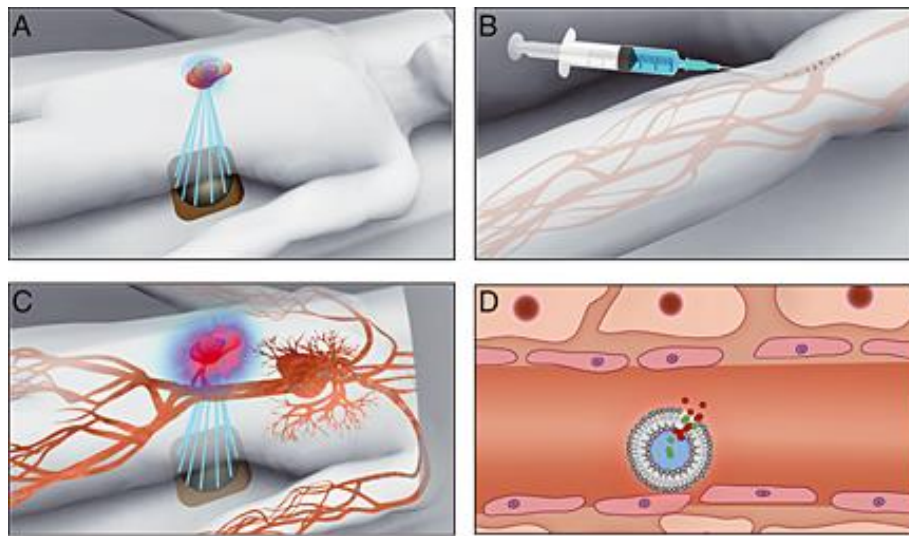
Representation of temperature-induced drug delivery using MR-HIFU in combination with TSLs that encapsulate drugs and MRI CAs. In picture A is shown the MRI-guided HIFU –induced hyperthermia of a localized tumor; in picture B the intravenous injection of the liposomes that are sensitive to temperature; in picture C and D the beginning of the localized release of drug and MRI contrast agent from the TSLs. The co-release of the CA enables the estimation of the local drug delivery using MRI. Figure from ⁴³.
